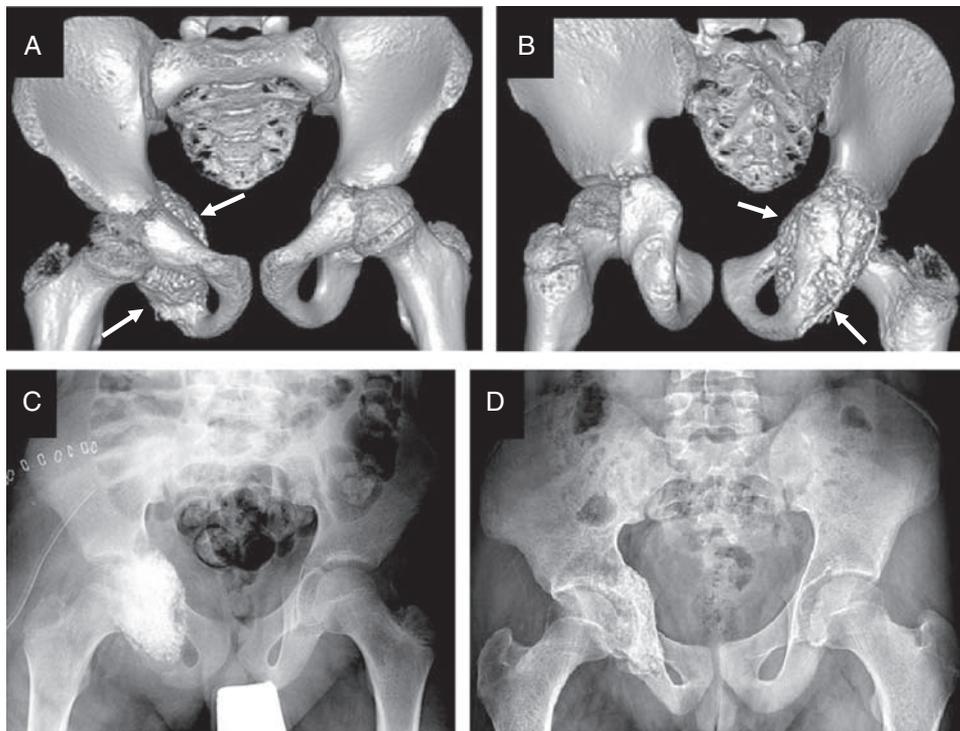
Anterior (A) and posterior (B) view of preoperative 3D computed tomography reconstruction of pelvis showing expansile lesion of left ischium (arrows). C, Postoperative x-ray following intralesional curettage and obliteration of cyst cavity with bone graft and substitute (tricalcium phosphate). D, Four-year follow-up x-rays showing healed cyst with incorporation of graft and remodeling.
